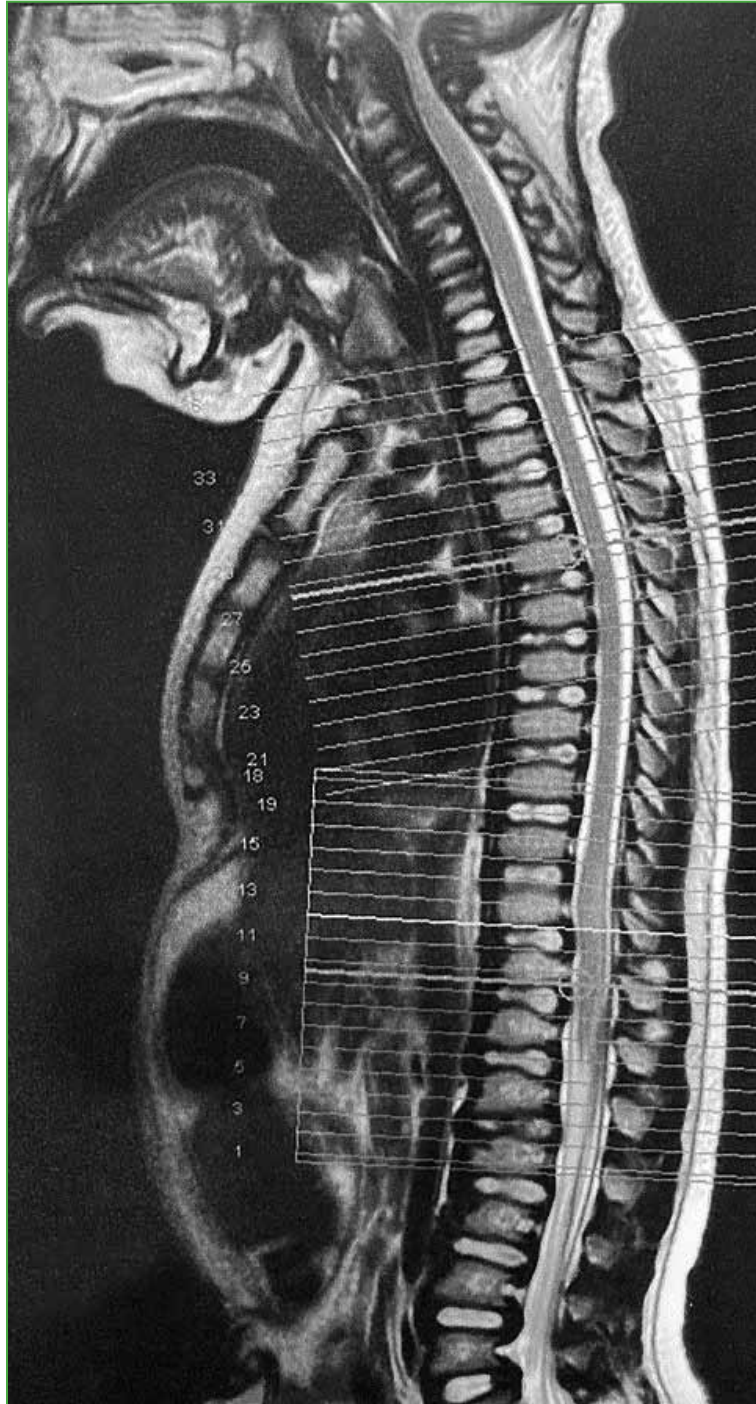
Magnetic resonance imaging of the complete spine, sagittal section. Posterior displacement of the nucleus pulposus, dysplasia of the vertebral bodies, and a decrease in spinal diameter at C0-2 are observed.
